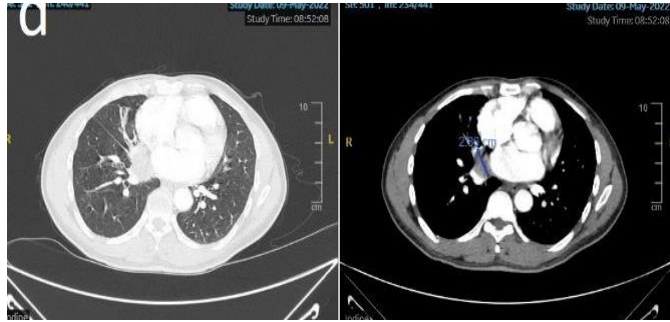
Thoracic CT scan evaluation on May 9th, 2022, third RECIST.
